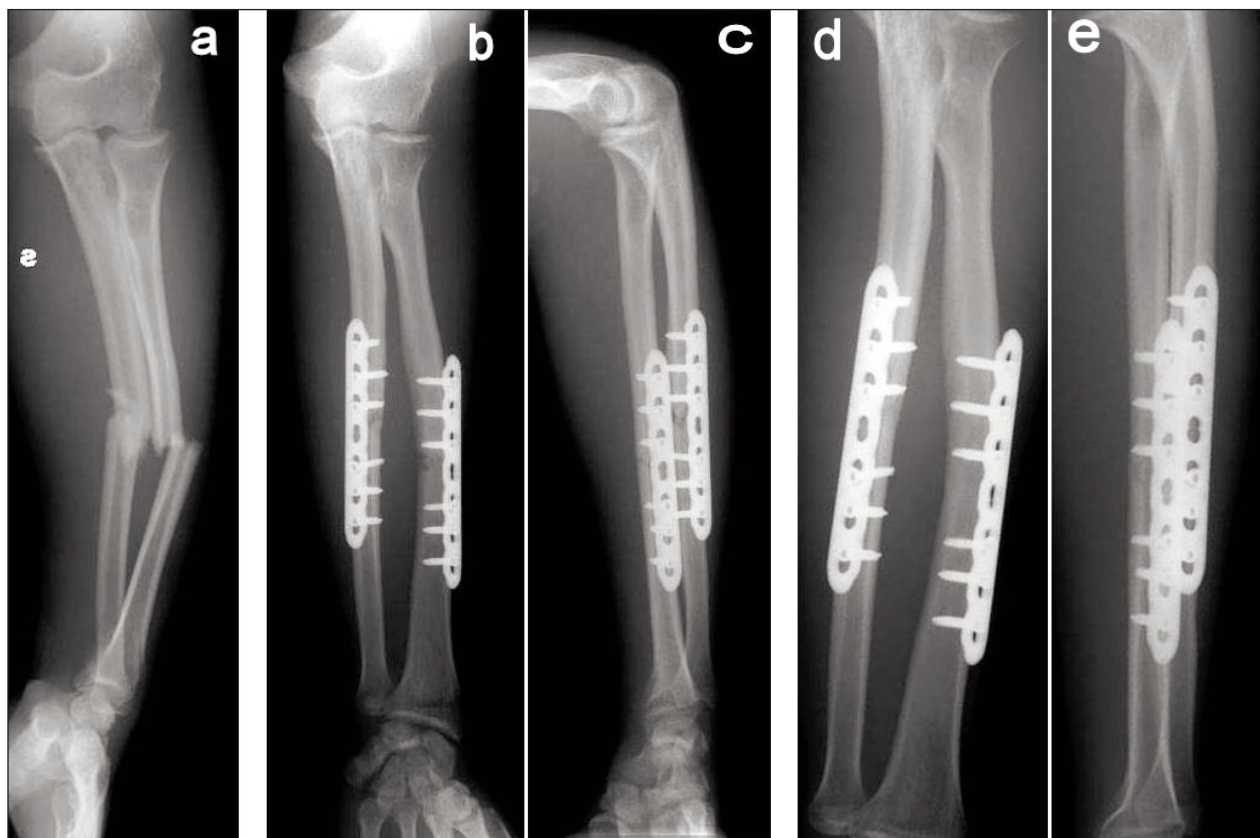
Case 36, male, aged 21: a-b) pre-operative X-ray; c-d) follow-up 1 month later; e-f) follow-up 8 months later
